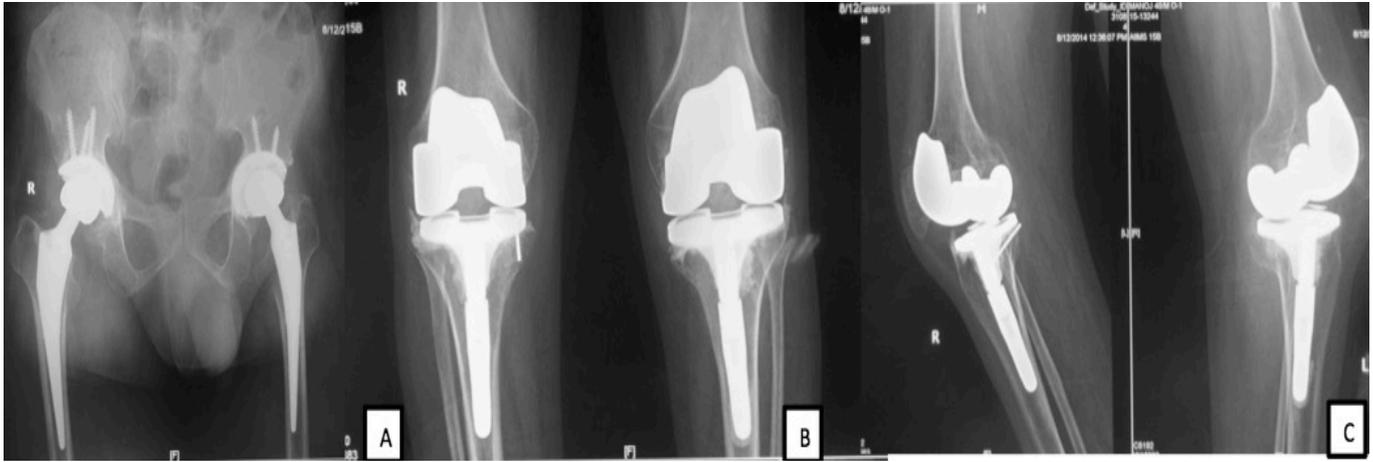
One year follow up X-ray showing (A) Anteroposterior view of the pelvis with both hips (B) Anteroposterior view of both the knees (C) Lateral view of both the knees. Note the heterotopic bone formation in the right hip as well as the left knee. However, the patient was asymptomatic.
